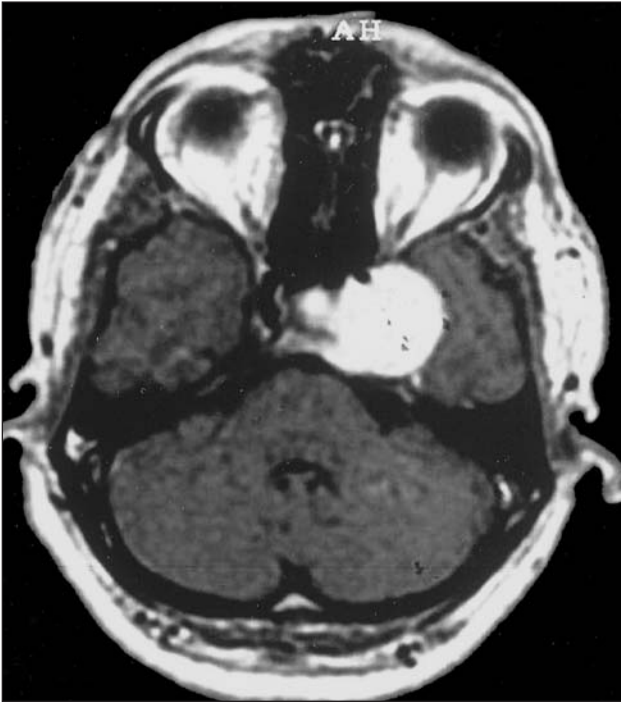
Case 2: Preoperative T1-weighted contrast axial MRI shows tumoral mass on the left temporal lobe related with cavernous sinus.
